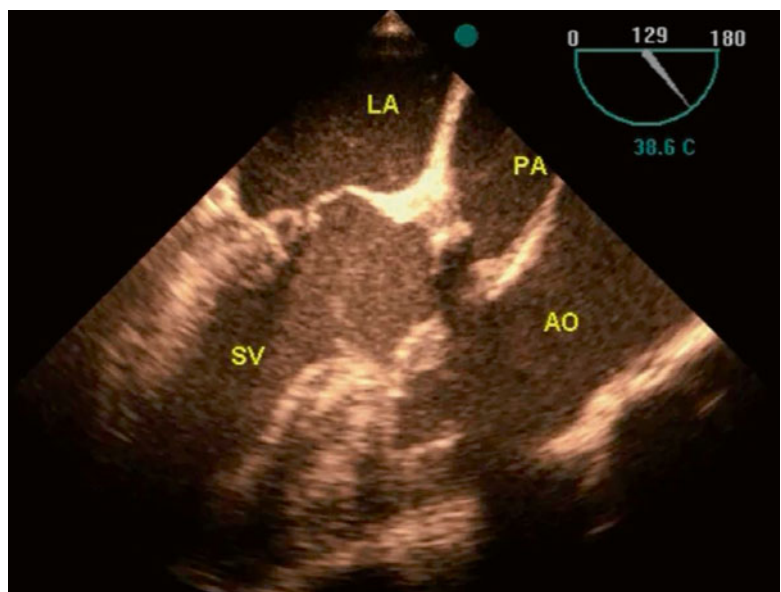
Transesophageal echocardiography in long axis view demonstrating transposition of great arteries and severe pulmonary stenosis. *LA* left ventricle, *AO* aorta, *PA* pulmonary artery, *SV* single ventricle
